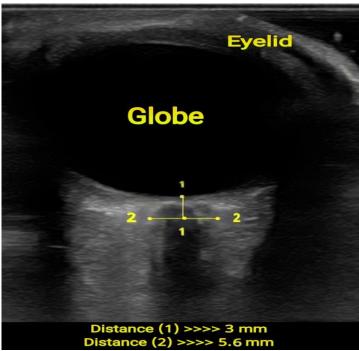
Sonographic measurement of ONSD of a case of the non-severe preeclampsia group.
